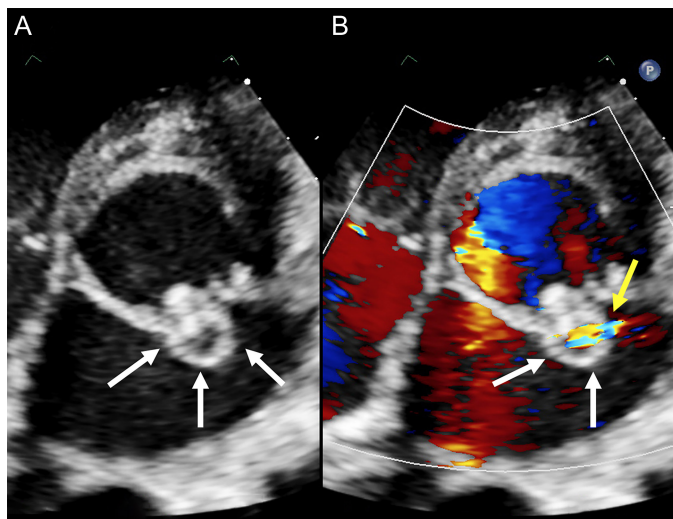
(A) Transthoracic echocardiogram modified short-axis view at the level of mitral anterior leaflet showing an aneurysm of middle scallop. (B) Transthoracic echocardiogram modified short-axis view at the level of mitral anterior leaflet with color Doppler showing abnormal flow through a ruptured aneurysmal segment. White arrows indicating aneurysm of anterior mitral leaflet; yellow arrows indicating a hole on the aneurysmal wall.
